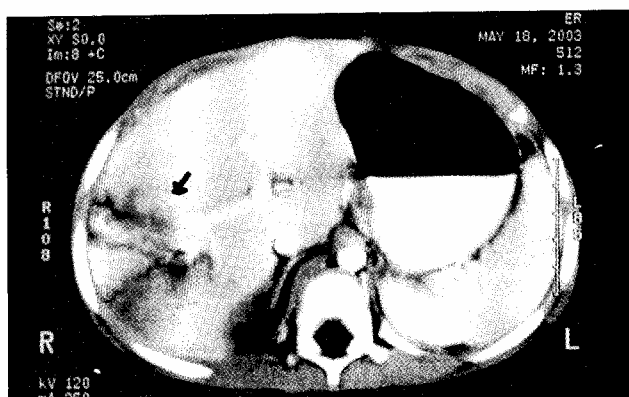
Computed tomogram abdomen demonstrating intra-hepatic hematomas grade III.
